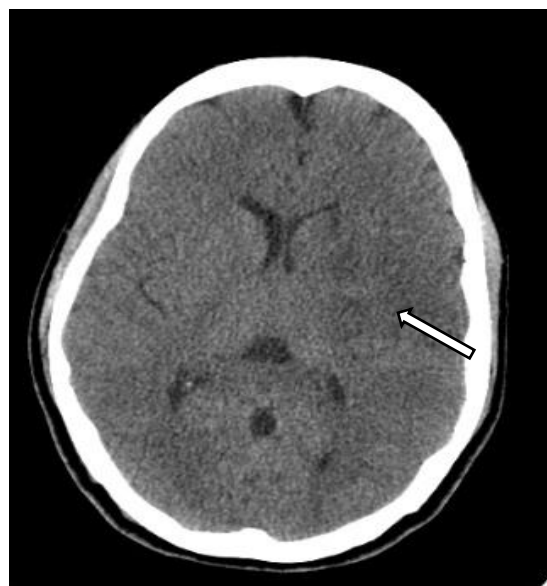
Plain CT Brain Axial view
